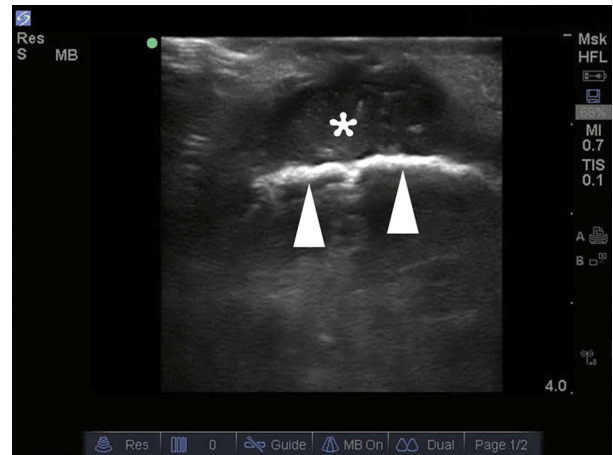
Bedside ultrasound demonstrating a fluid collection (asterisk) adjacent to the mandible (arrowheads). Note the irregular cortical surface of the mandible.
